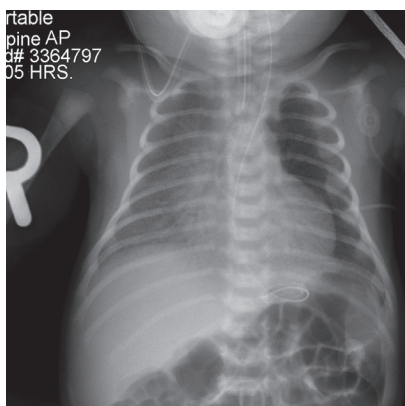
Chest X-ray for visualization of residual pneumothorax.
